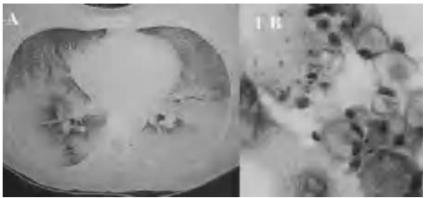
A*) Section of the computed tomography scan of the chest performed on admission to the intensive care unit, showing the panlobar alveolar pattern with air bronchogram, and *B*) a sample of the bronchoalveolar lavage showing microvacuolar inclusions in the alveolar macrophages.
